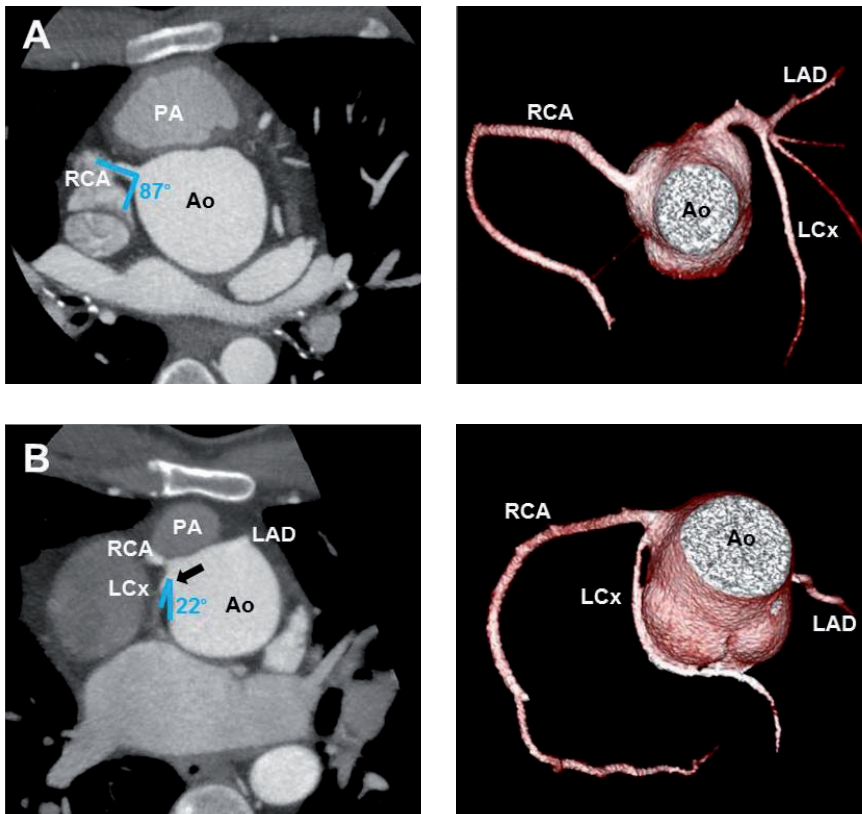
Example of the coronary angle measurement on CTA.
